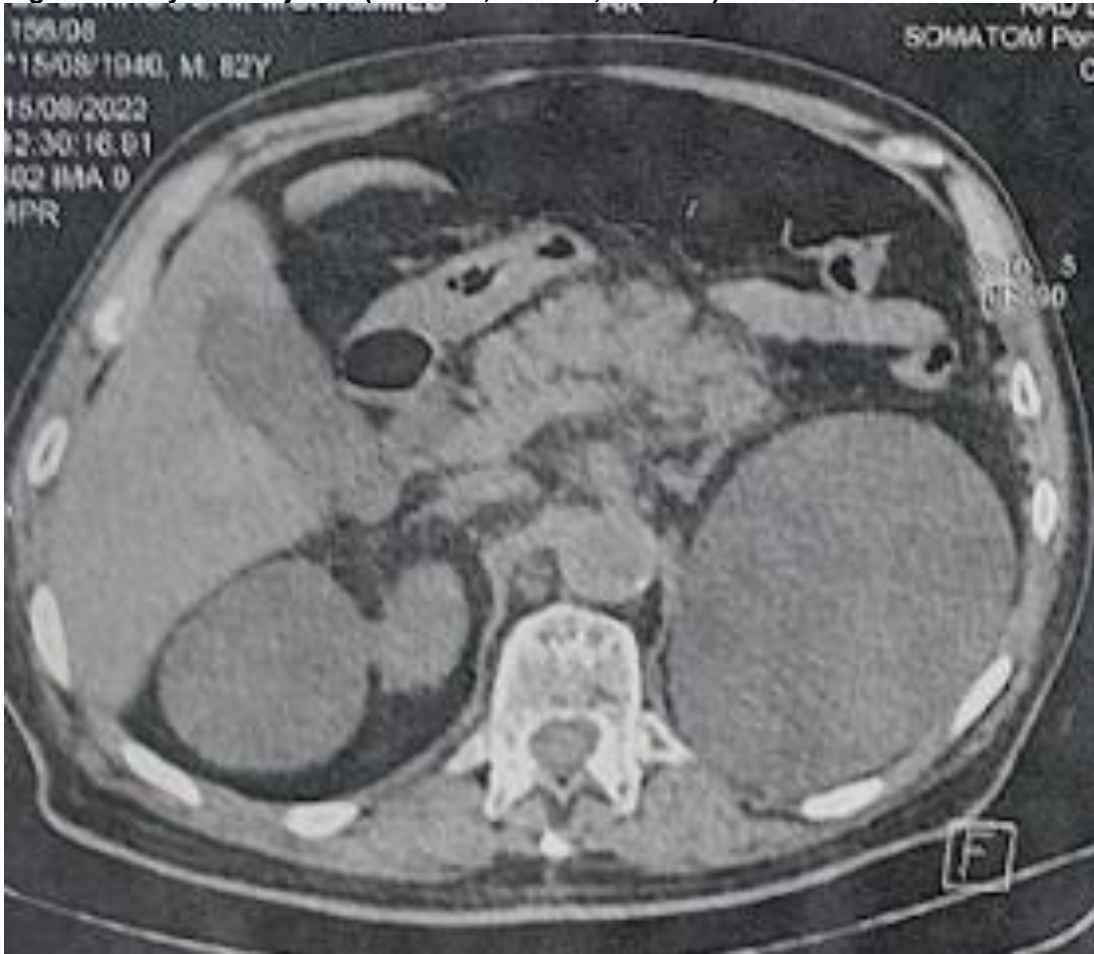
CT scan slice showing Balthazar stage D pancreatitis
